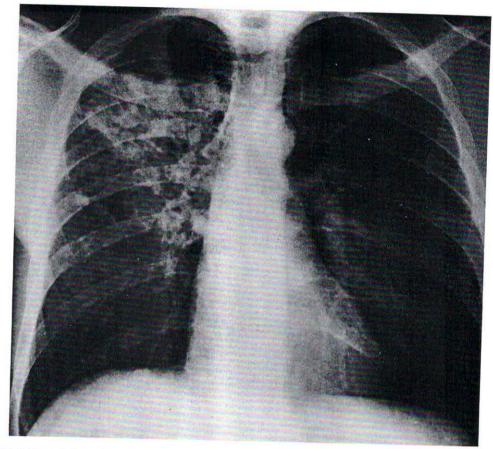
Frontal view, chest radiograph, showing the typical findings of endogenous reactivation tuberculosis in an immunocompetent patient. Note the upper lobe location and cavitation.
